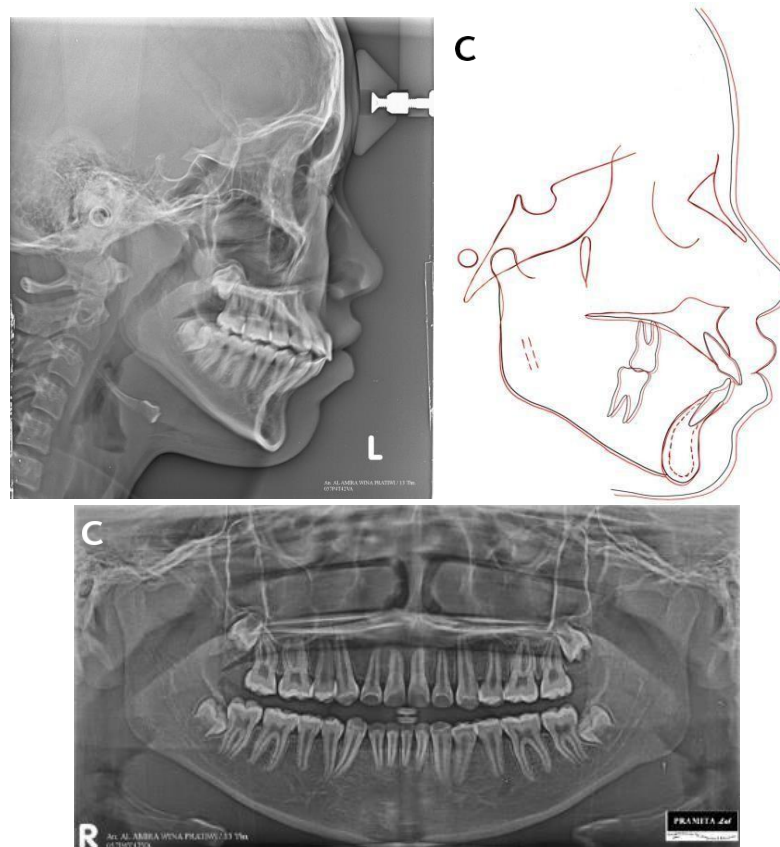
Pretreatment radiographs and tracing. A: Lateral cephalometric radiograph; B, superimpose cephalometric tracing; C, a panoramic radiograph.
